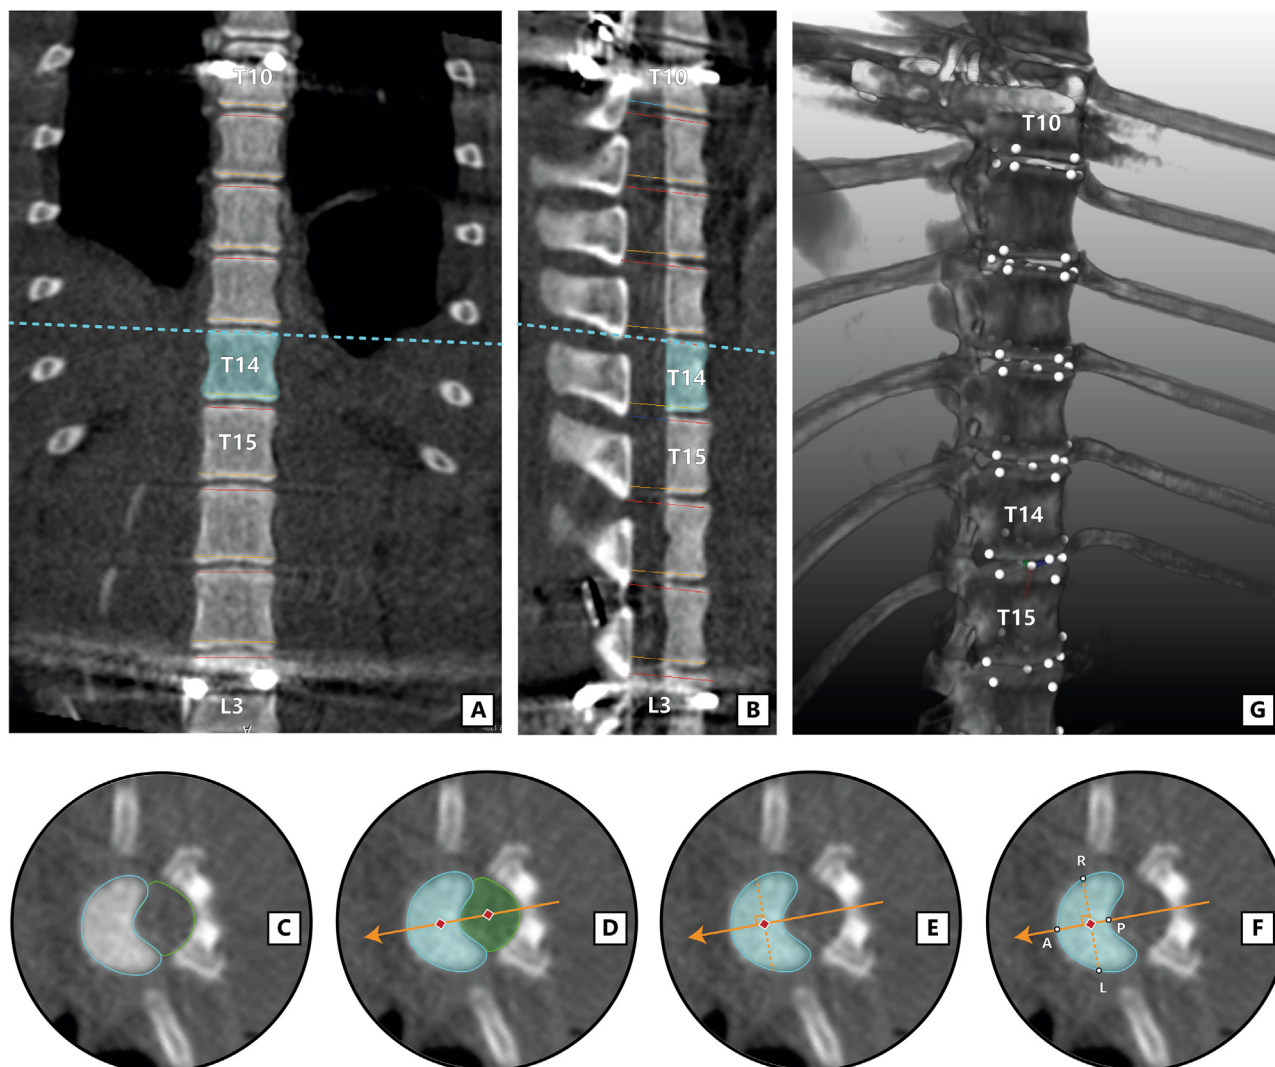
Radiographic measurements. The endplates of each investigated vertebra (T14 in example above) are segmented. (A–B) First, lines are drawn that correct for coronal (A) and sagittal (B) tilt of each endplate, so that the corresponding axial view corresponds to the true axial plane [3]. (C) In this plane, the endplate (blue) and spinal canal (green) are manually segmented. (D) The ScoliosisAnalysis v4.1 software computes the centroid of both the vertebral body and the spinal canal (red diamonds). The line through these centers defines the vertebral anterior-posterior axis (orange arrow). (E) A line perpendicular to this axis, intersecting the centroid of the vertebral body is then constructed (dashed orange line). (F) Where these two lines intersect the segmentation of the vertebral body, the following points are drawn: anterior (A), posterior (P), left (L) and right (R). (G) The x-, y- and z-coordinates of each point of each endplate are extracted, and relevant lengths and angles between endplates are calculated.
